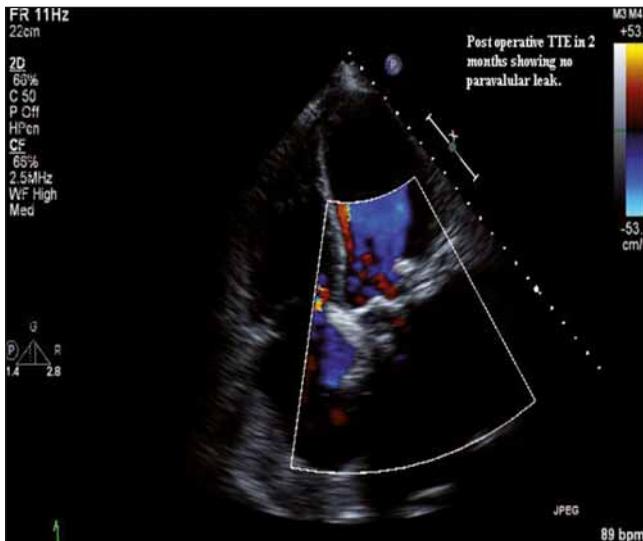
Postoperative transthoracic echocardiography at 2 months showing no mitral paravalvular leak.
